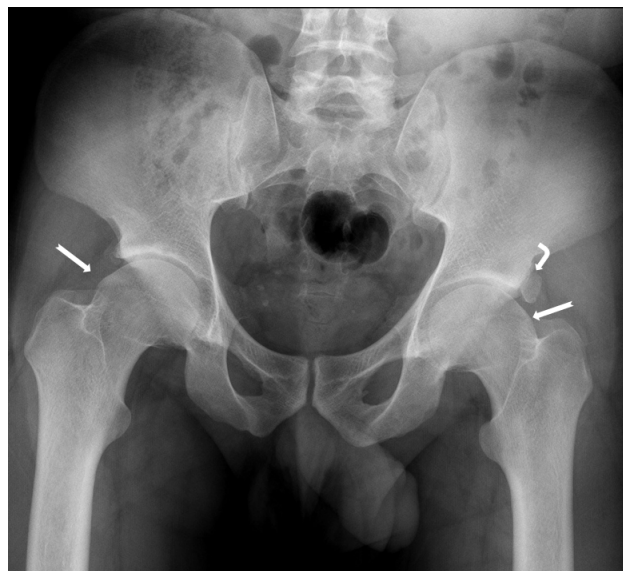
Anteroposterior pelvis radiograph of a 28-year-old male patient with clinical findings of femoroacetabular impingement syndrome on his right hip. Note that both femoral head-neck junctions demonstrate a “cam” morphology (arrows). A large os acetabulum (curved arrow) is present on the left side.
